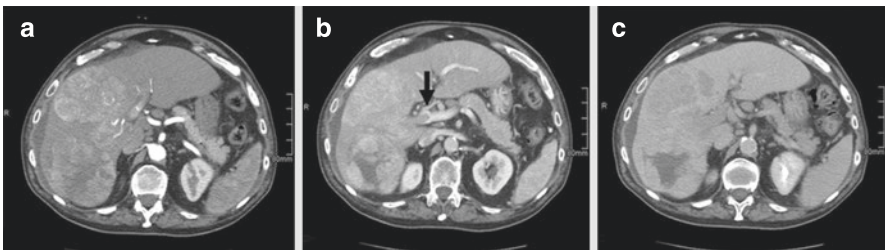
A voluminous lesion subverts the structure of the right liver, with imaging compatible with hepatocellular carcinoma appreciable on the CT axial images in the arterial (a), portal venous (b) and delayed (c) phases. Macrovascular invasion is observed with neoplastic thrombosis causing occlusion of the right portal vein, subocclusion of the left portal vein and the common portion of the mesenteric splenic confluence (black arrow). The figure is published with the patient’s authorization
